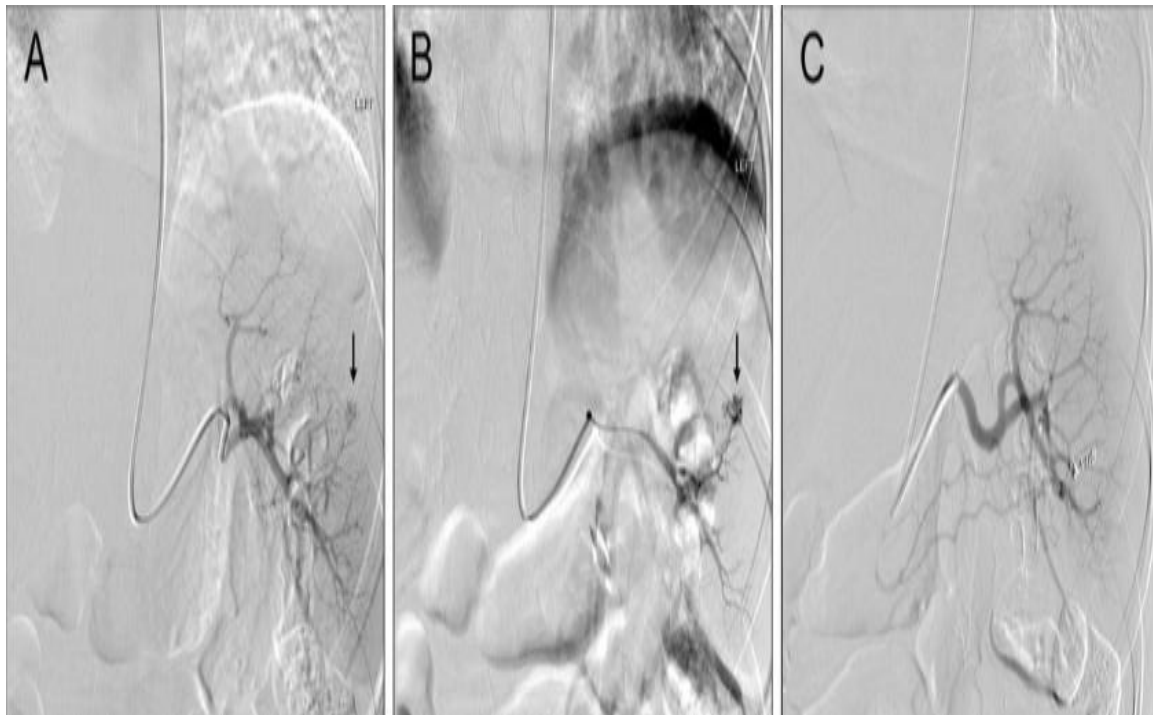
Patient with blunt splenic injury who underwent angioembolization for contrast blush on CT scan. (A) The diagnostic angiogram confirms the active bleed. (B) Selective angiogram of the splenic segment with bleeding. (c) Completion angiogram after distal coil deployment (1).
